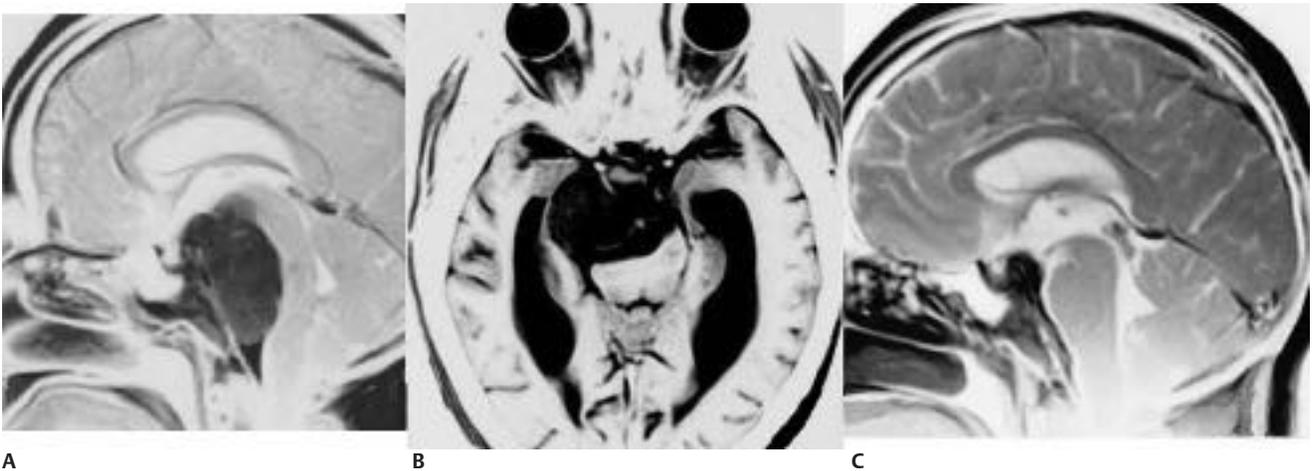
Magnetic resonance imaging (MRI) of a clival meningioma that originated medially and was not able to be removed totally because of the absence of multiple arachnoid layers against the upper brain stem. (A) Preoperative enhanced sagittal MRI. (B) Preoperative axial T2 MRI. (C) Postoperative sagittal enhanced MRI demonstrating a small residual at the dorsum sellae.
